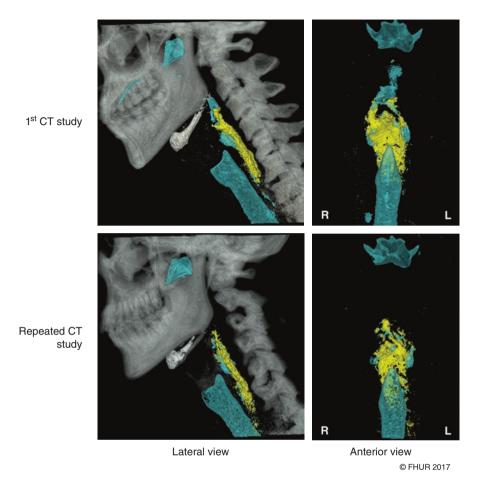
Repeat 3D-CT images of swallowing 8 ml of nectar-thickened liquid, taken at the time of highest hyoid anterosuperior movement. The amount of air (blue) in the pharyngeal space while the bolus material (yellow) passed through the UES inlet during swallowing was obviously decreased
